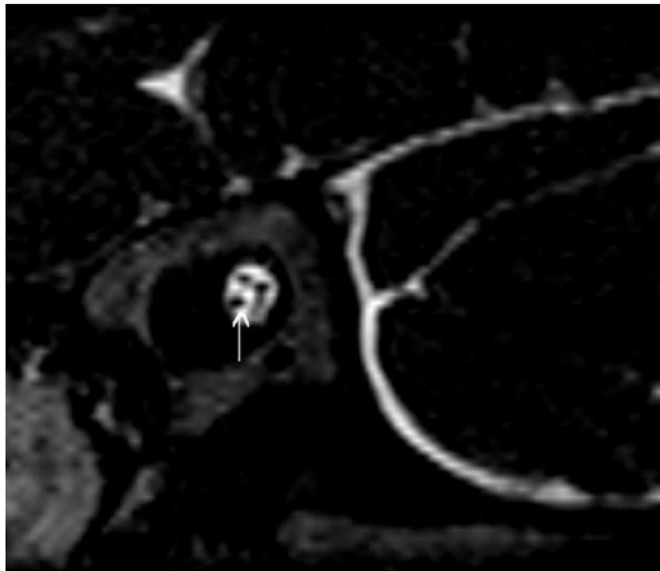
White arrow shows Cochlear nerve in oblique sagittal reformatted image on heavily T2WI MRI scan.
